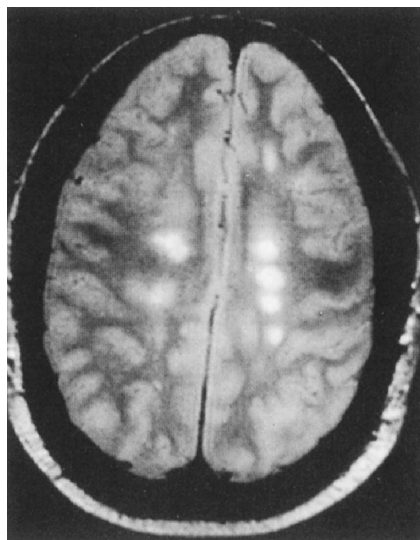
■ Axial T2-weighted image shows ovoid hyperintense lesions in both hemispheres.
